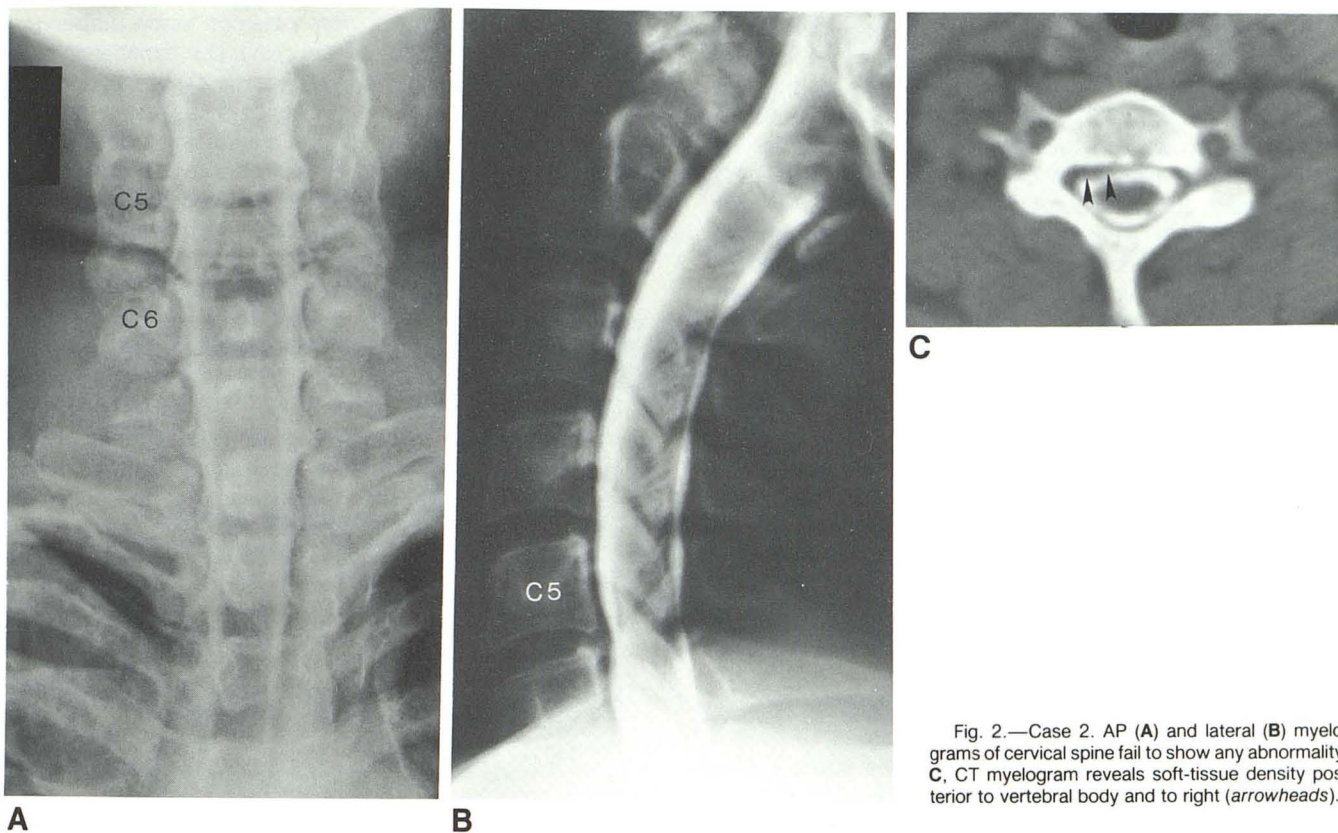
Case 2. AP (A) and lateral (B) myelograms of cervical spine fail to show any abnormality. C, CT myelogram reveals soft-tissue density posterior to vertebral body and to right (arrowheads).
